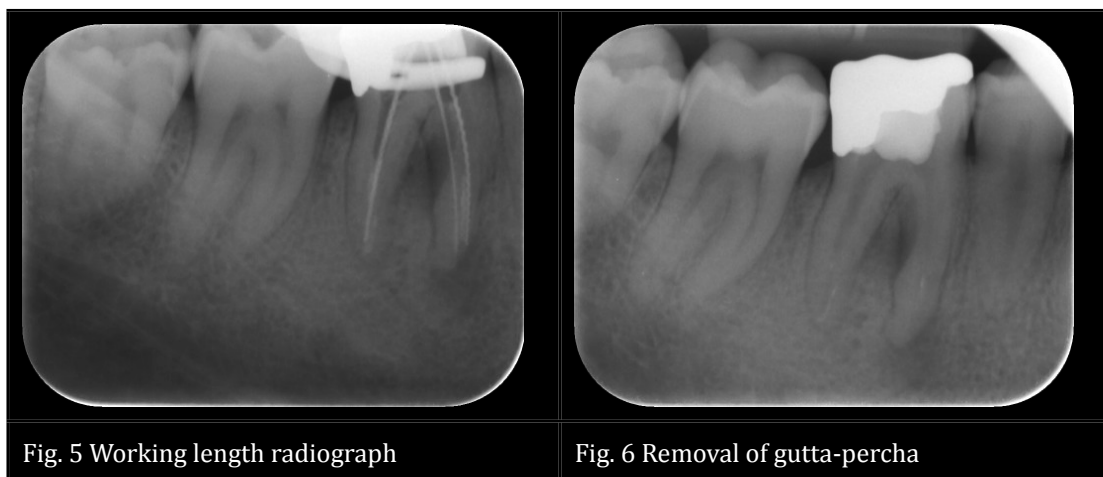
Working length radiograph
